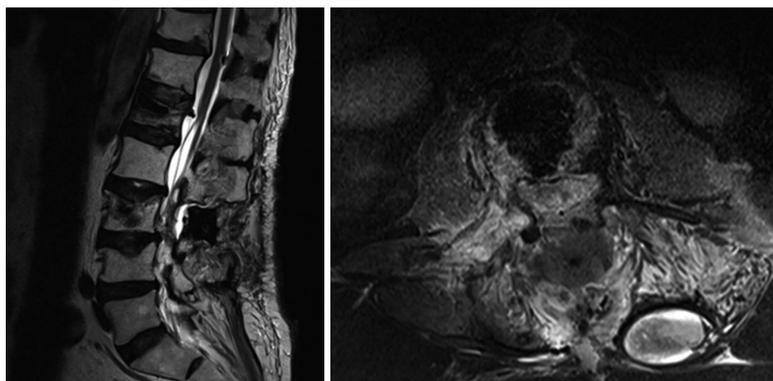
Postoperative T2 weighed magnetic resonance imaging on sagittal and axial plane showing the proper execution of the bilateral laminectomy at L2 L3 as well as the removal of the intradural lesion.
